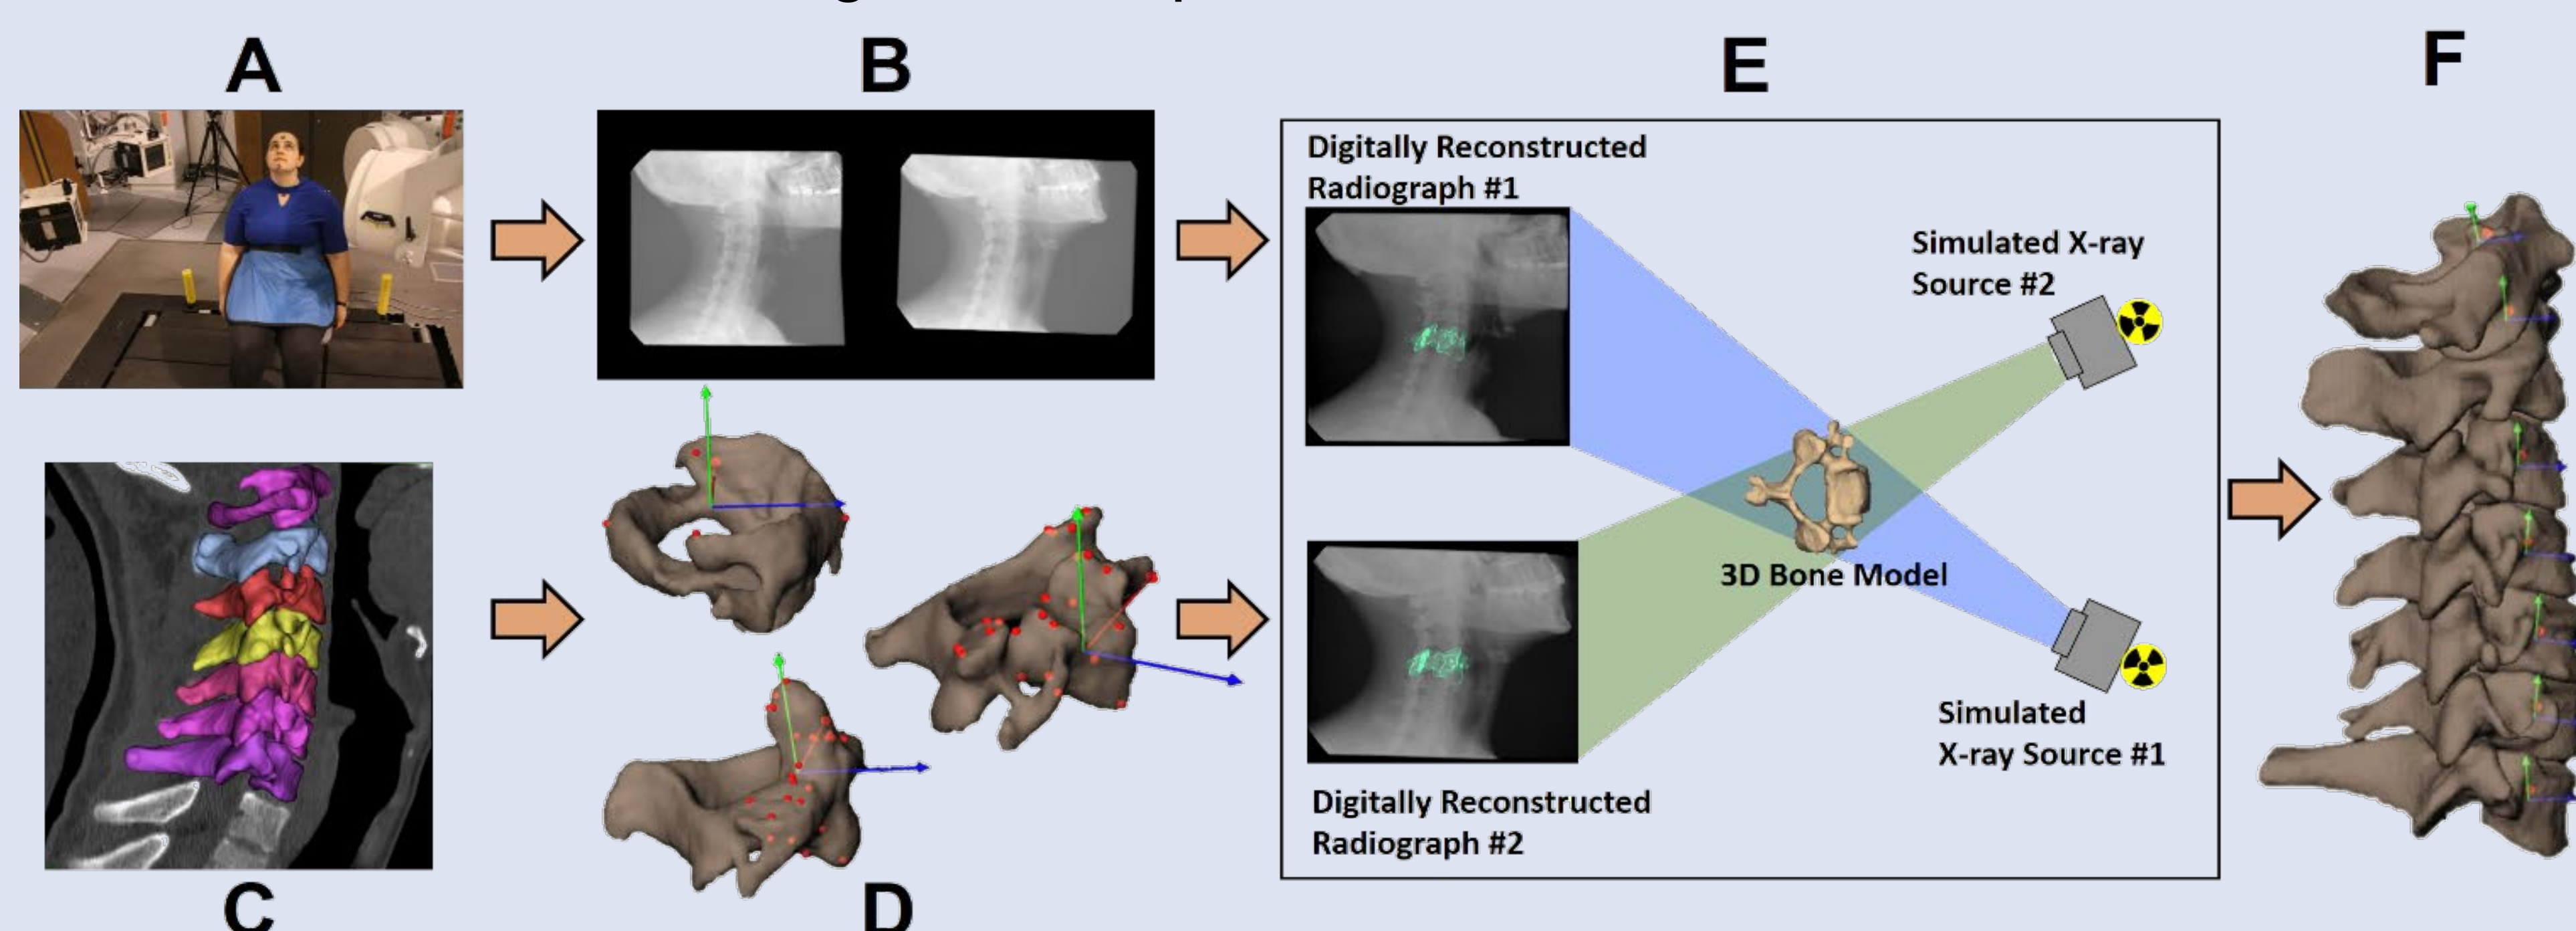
Biplane radiography data collection and processing. (A) Participants performed full ROM flexion/extension and axial rotation movements while (B) synchronized biplane radiographs were collected at 30 images per second (70kV, 125mA, 2.5ms pulse width). (C) C1 to C7 CT scans were collected and (D) used to create 3D bone models. (E) Bone motion was determined using a validated CT model-based tracking process. (F) Six DOF kinematics were calculated throughout the full ROM.
